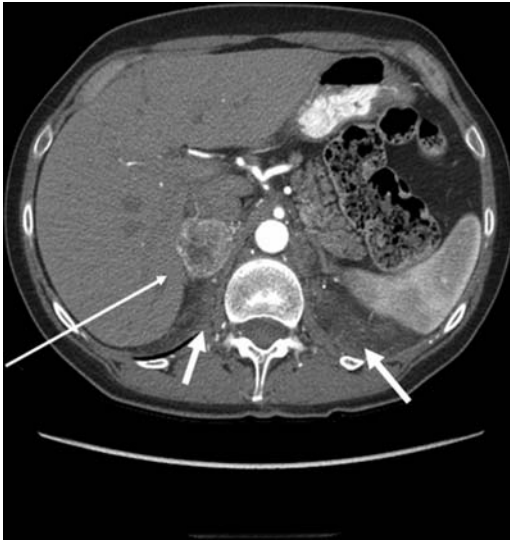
CT of patient with pheochromocytoma (denoted by *thin arrow*) of brown fat changes (denoted by *thick arrows*) associated with pheochromocytoma.
